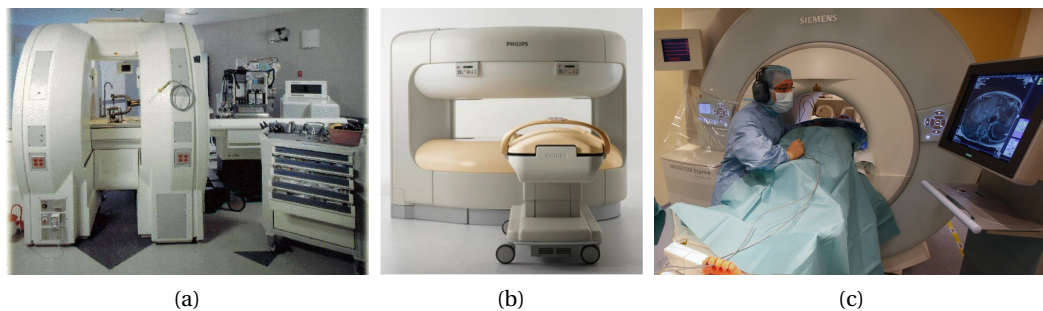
Interventional MRI scanners. (a): Double donut MRI scanner (Signa SP, GE, Little Chalfont, UK). Reprinted from [SGKU02]. (b): MRI scanner with horizontal gap (Panorama, Philips, Best, Netherlands). Reprinted from [htt13a]. (c): Open bore MRI scanner (MAGNETOM Espree, Siemens AG, Erlangen, Germany) with the physician accessing the patient through the tunnel opening.
